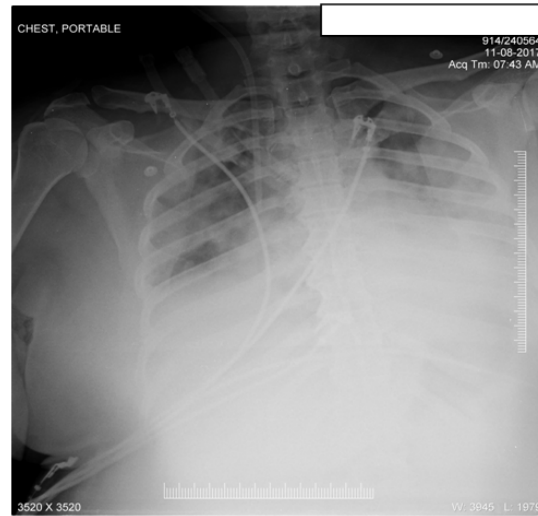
X-ray chest 11.08.2017 (case 1) showing bilateral pneumonitis with? pleural effusion
